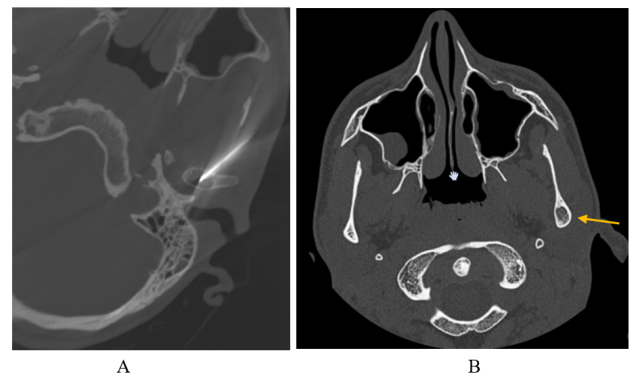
Cone beam CT for needle guidance and post sclerotherapy follow up CT. A): Cone beam CT demonstrates needle in appropriate position within the left mandibular ramus ABC; B): Follow up CT facial bones demonstrates diffuse sclerosis of the left mandibular ramus lesion and reduction in size (yellow arrow)
